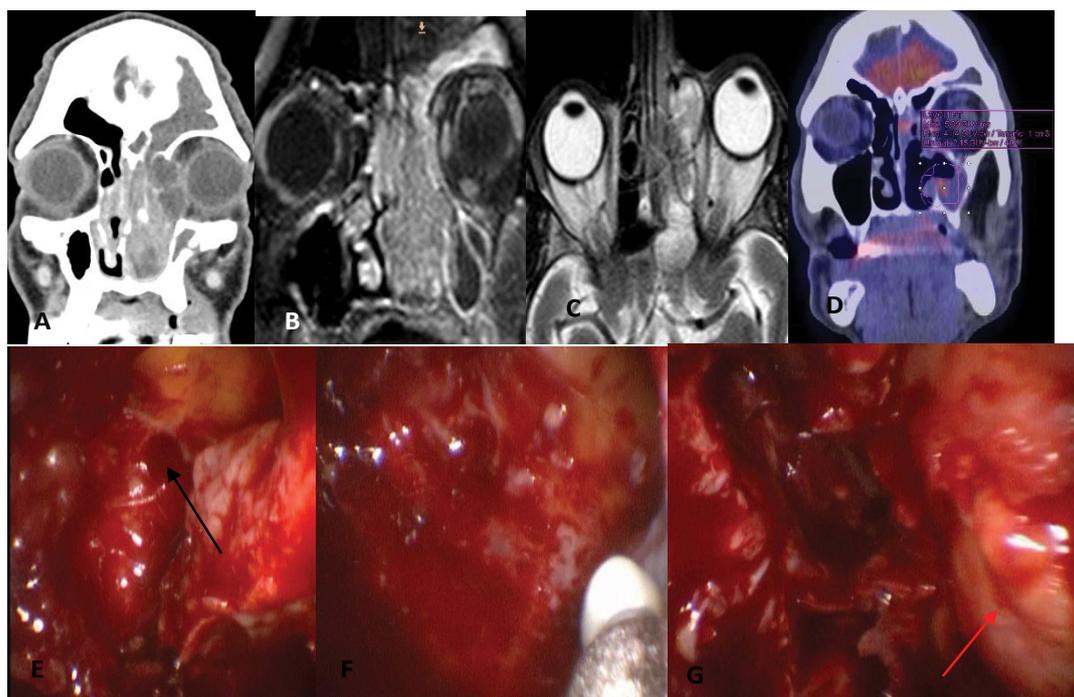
Synchronous squamous cell carcinoma with IP (T3N0M0). (A) CT showing the tumor in the nasal cavity and the involvement of the innerwall of the orbit; (B) Coronal MRI showing the tumor in the nasal cavity and ethmoid; (C) Axial MRI showing the involvement of the ethmoid and the internal wall of the orbit; (D) PET after endonasal resection of the IP (uptake in the medial wall of the maxillary sinus and nasal septum); (E,F) Endoscopic view of the medial maxillectomy (arrow); (G) Endoscopic view after resection of the lamina papyracea, showing the exposed periorbita (arrow) and dissection of the skull base.
